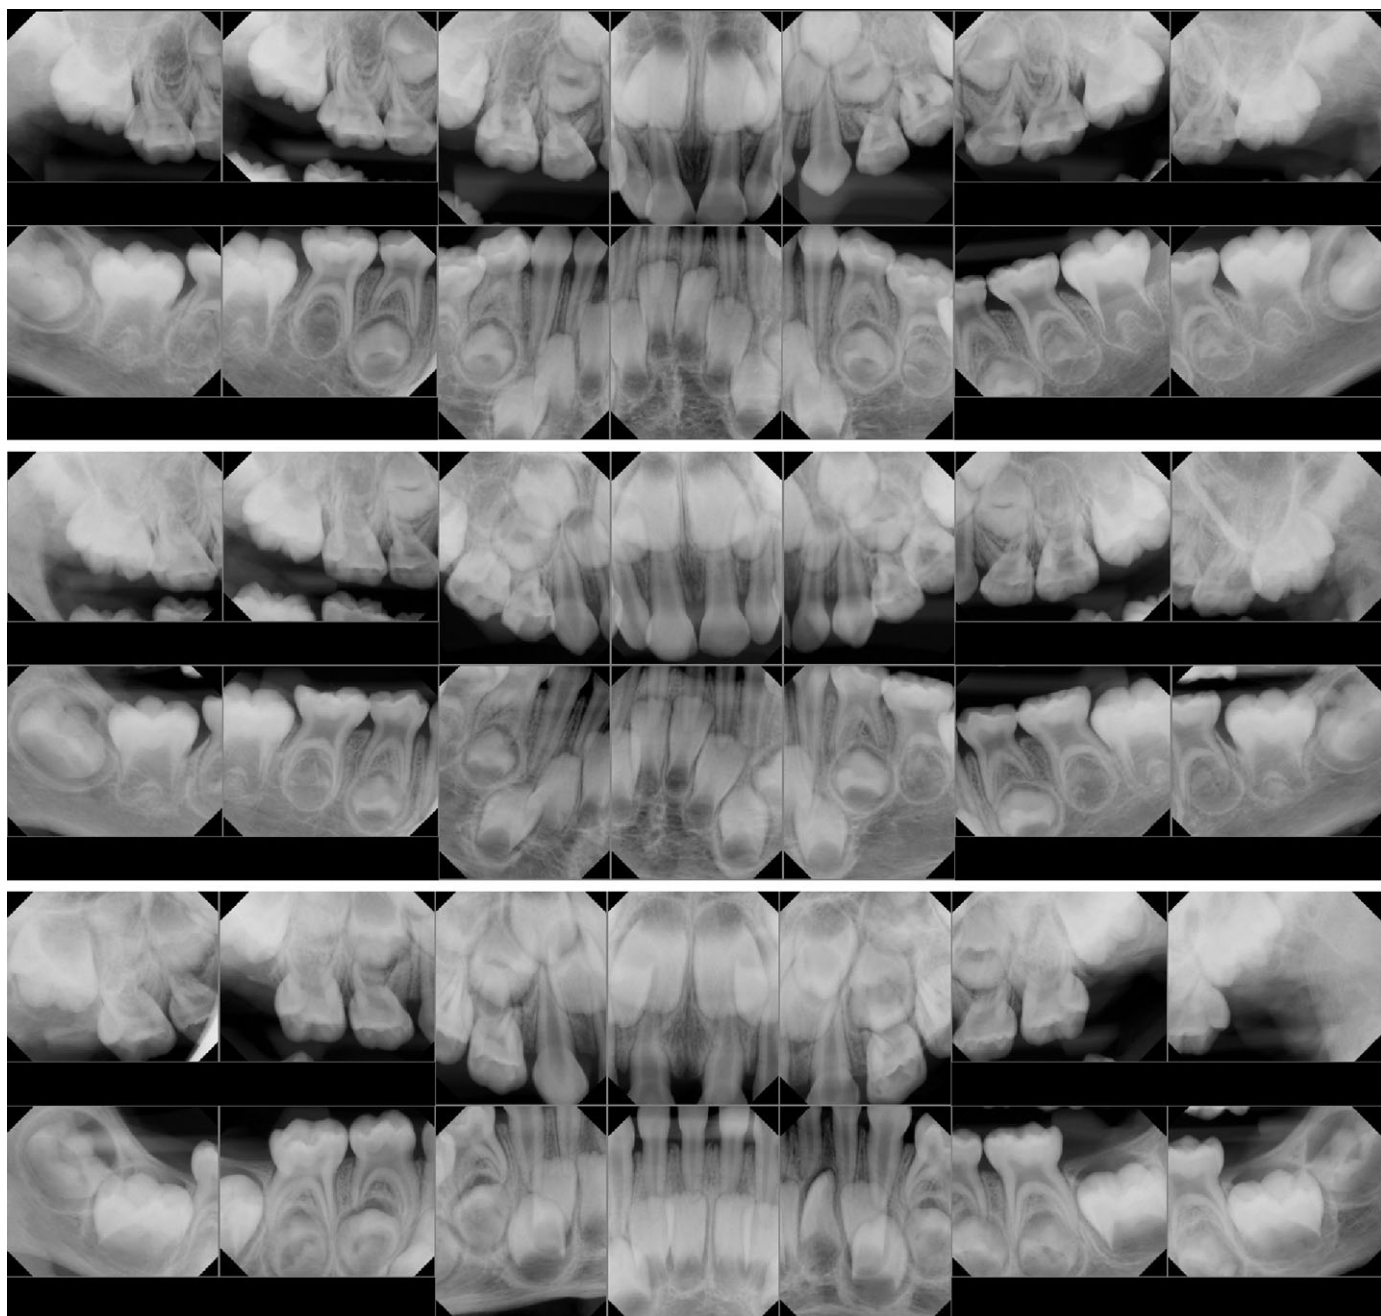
"Child A" radiographs (top); "Child B" radiographs (middle); "Child C" radiographs (bottom).
